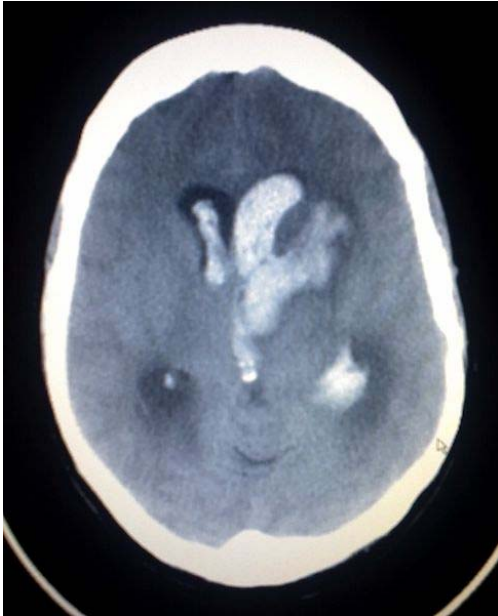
5 CT Scan of Hemorrhagic Stroke. Reproduced by permission under GNU public license.
